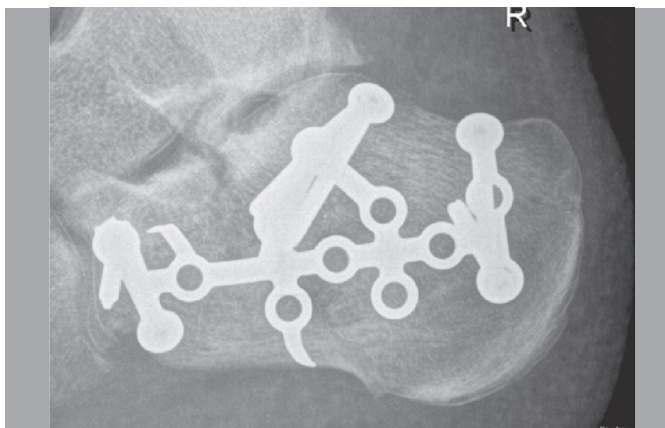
Lateral X-ray postoperatively LCP.
